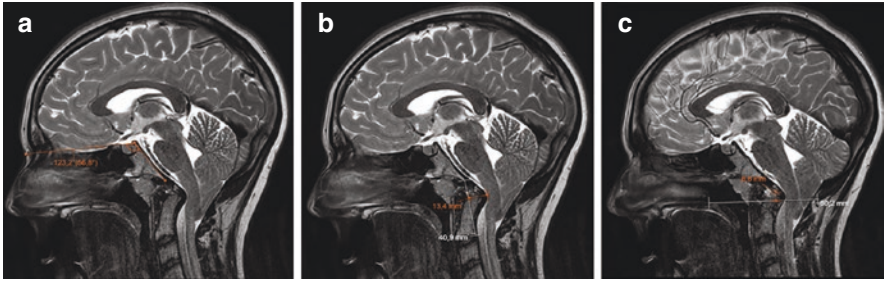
MRI of Chiari type I malformation with basilar invagination, platybasia, and significant ventral brainstem compression with medullary kinking. (a) Pathological clivo-axial angle (CXA) of $<125^\circ$ indicating platybasia; (b) pB-C2 measurement of >9 mm indicating ventral brainstem compression; (c) chamberlain line with displacement of the odontoid of more than 3 mm toward the foramen magnum indicating basilar invagination
